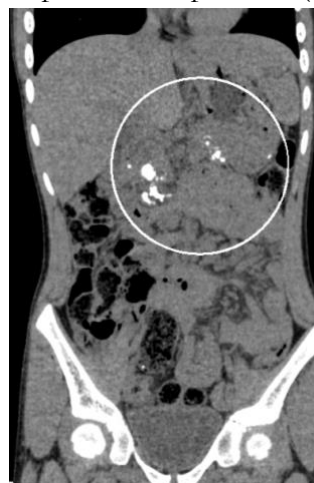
Coronal view of abdominal CT scan with contrast showing multiple pancreatic stones (circle mark).
